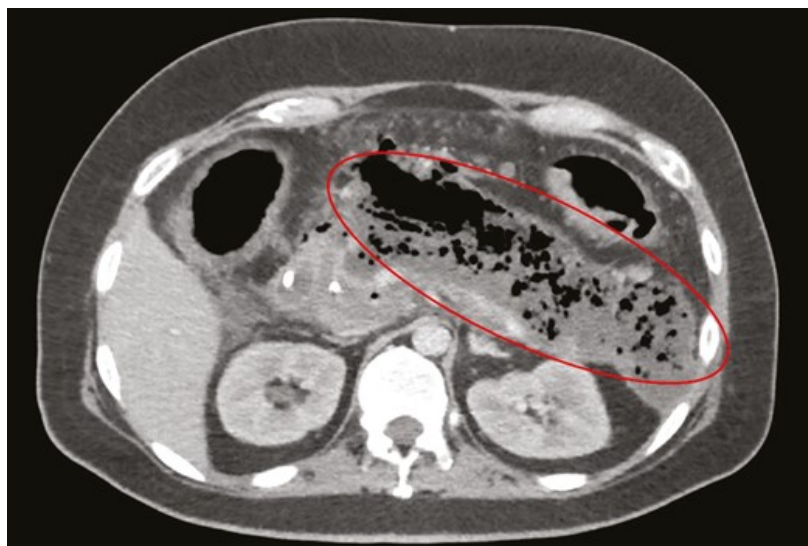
Contrast-enhanced computed tomography demonstrating an infected pancreatic necrosis with diffuse gas bubbles throughout the acute necrotic collection (oval).
